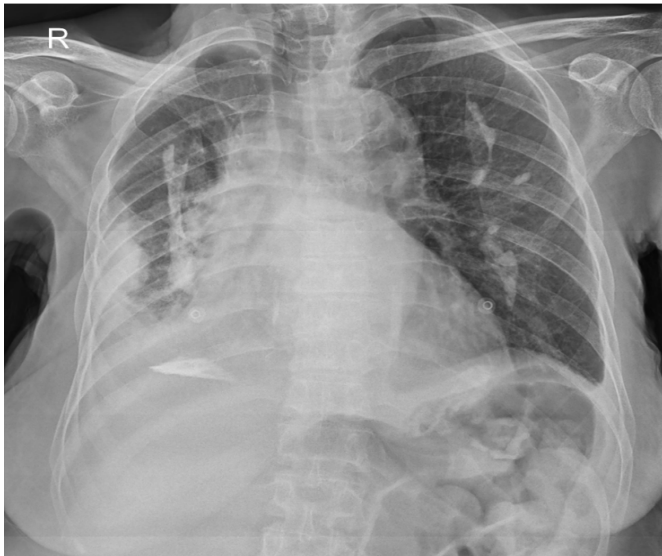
Posteroanterior chest radiograph demonstrating asymmetric right-sided pleural abnormalities with associated volume loss, consistent with known pleural disease
